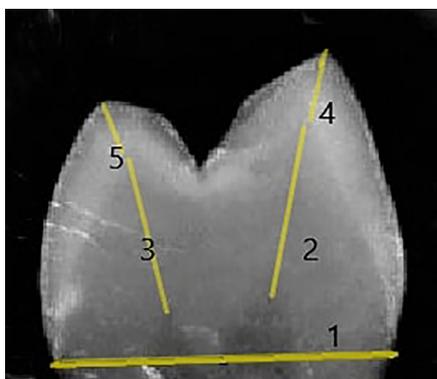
Measurement in periapical radiography. 1: Maximum cervical crown width, 2: Buccal dentin thickness, 3: Palatal dentin thickness, 4: Buccal enamel thickness, 5: Palatal enamel thickness.
